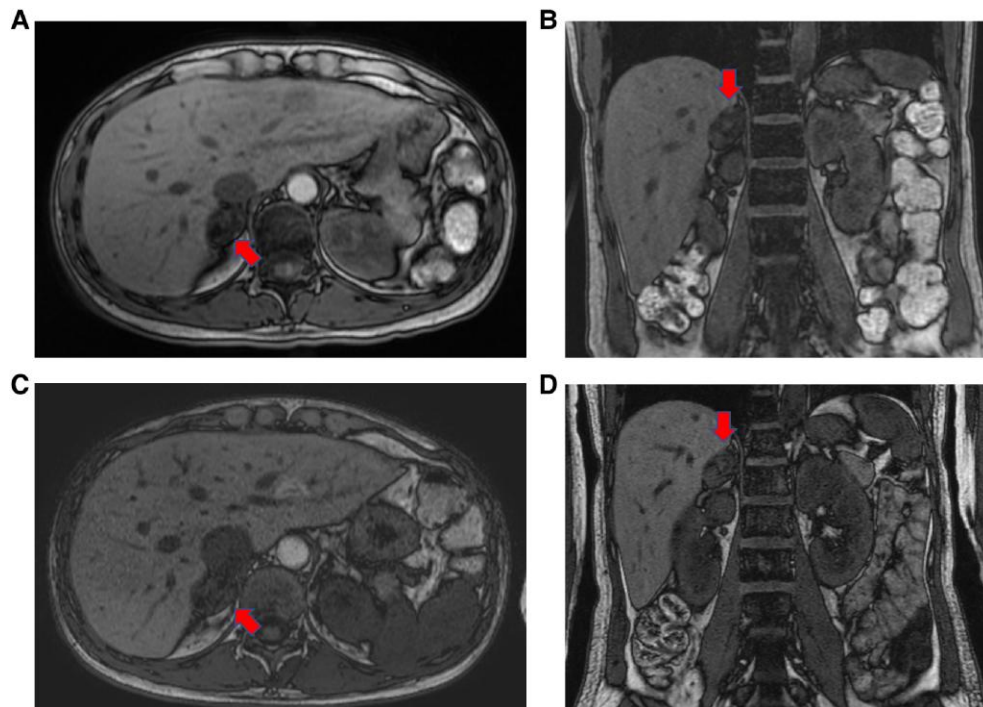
A, B, Adrenal gland on magnetic resonance imaging before pregnancy (T1 weighted, out of phase). Solid arrows indicate the right adrenal mass (34 mm x24 mm x22 mm). C, D, Adrenal gland on magnetic resonance imaging at 14 weeks of pregnancy (T1 weighted, out of phase). Solid arrows indicate the right adrenal mass (32 mm x24 mm x21 mm). There were no remarkable changes in size or features between examinations.
